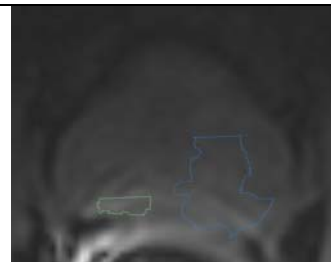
DCE-MRI with tumor boundaries delineated by radiologist 1
